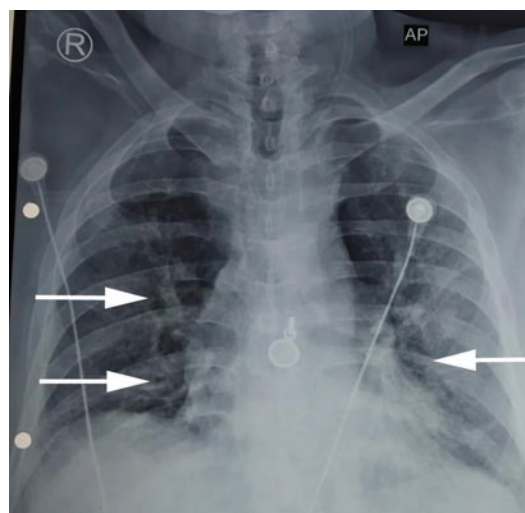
The chest X-ray (AP-view) of a 75-year-old man with COVID-19. White arrows show extensive opacities in bilateral lungs.
